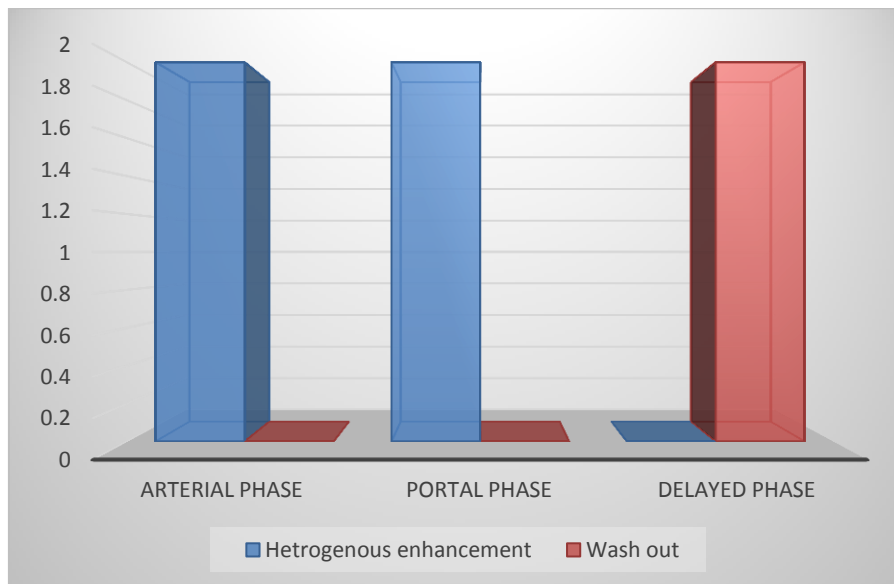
graph showing pattern of enhancement of hepatic adenoma by dynamic MRI.
